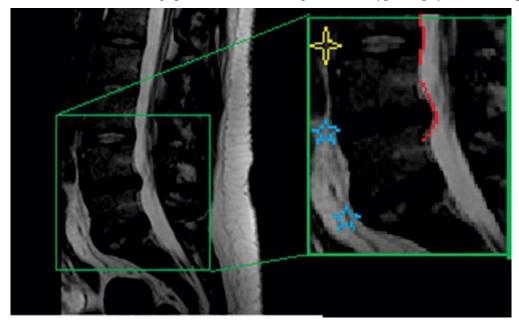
A sagittal T2-weighted MRI image demonstrating the darker discs at the L4-L5 and L5-S1 levels (blue stars), indicating dissection and degeneration, contrasted with the brighter signal within the L3-L4 disc, denoted by the yellow star. The normal posterior disc border at L3-L4 is contrasted with the protrusion of the L4-L5 disc (shown by red line). (Courtesy of https://doi.org/10.1155/2012/413913 Diagnostic Testing for Degenerative Disc Disease by Michael W. Hasz)
